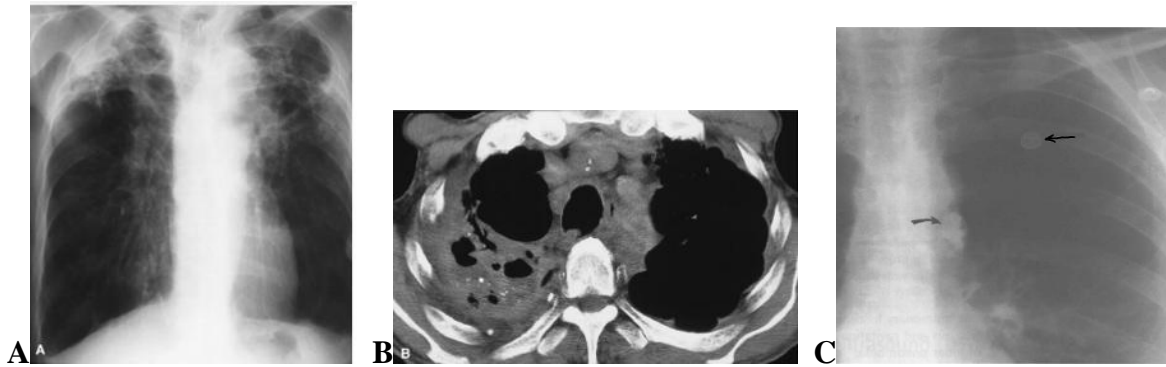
Postprimary (reactivation) tuberculosis. (A) Frontal chest film reveals hyperinflation with marked fibrotic and cavitary disease in the upper lobes with severe volume loss. In general, thin-walled cavities (<5 mm) tend to be infective and, when thick-walled (<10 mm), squamous cell carcinoma of the lung enters into the differential diagnosis. (B) A CT scan through the lung apices demonstrates consolidative and cavitary changes with air and fluid levels and pleural and parenchymal calcifications. (C) Primary tuberculosis of the lungs: Ghon complex. There is a calcified granuloma in the parenchyma left upper lobe (straight arrow), with a calcified lymph node in the hilar region (curved arrow).
